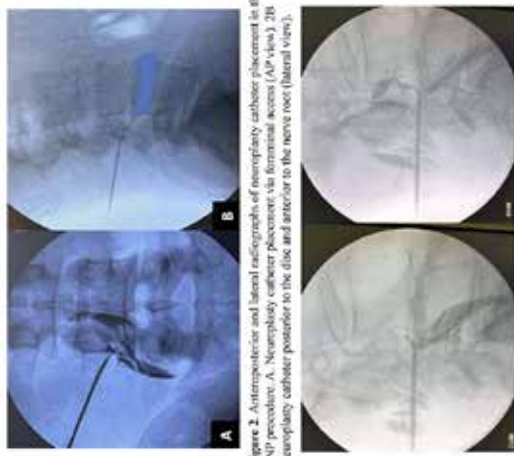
Anteroposterior and lateral radiographs of neuroplasty catheter placement in the PNP procedure. A. Neuroplasty catheter placement via foraminal access (AP view). B. Neuroplasty catheter posterior to the disc and anterior to the nerve root (lateral view).
